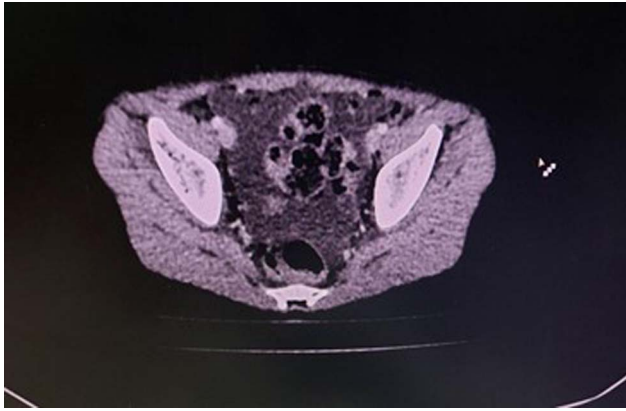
Computed tomography scan of the abdomen showing ascites.
